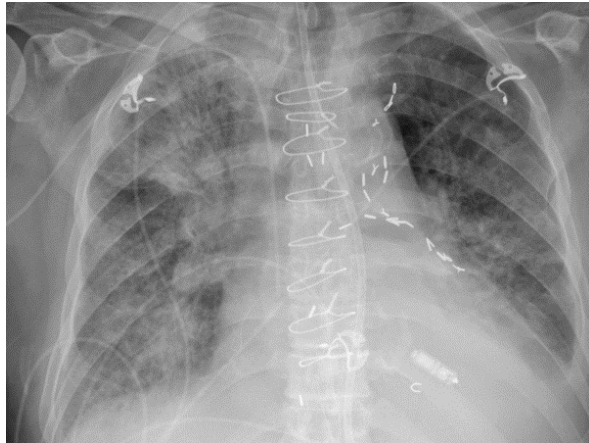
Chest x-ray done on 11/18.
